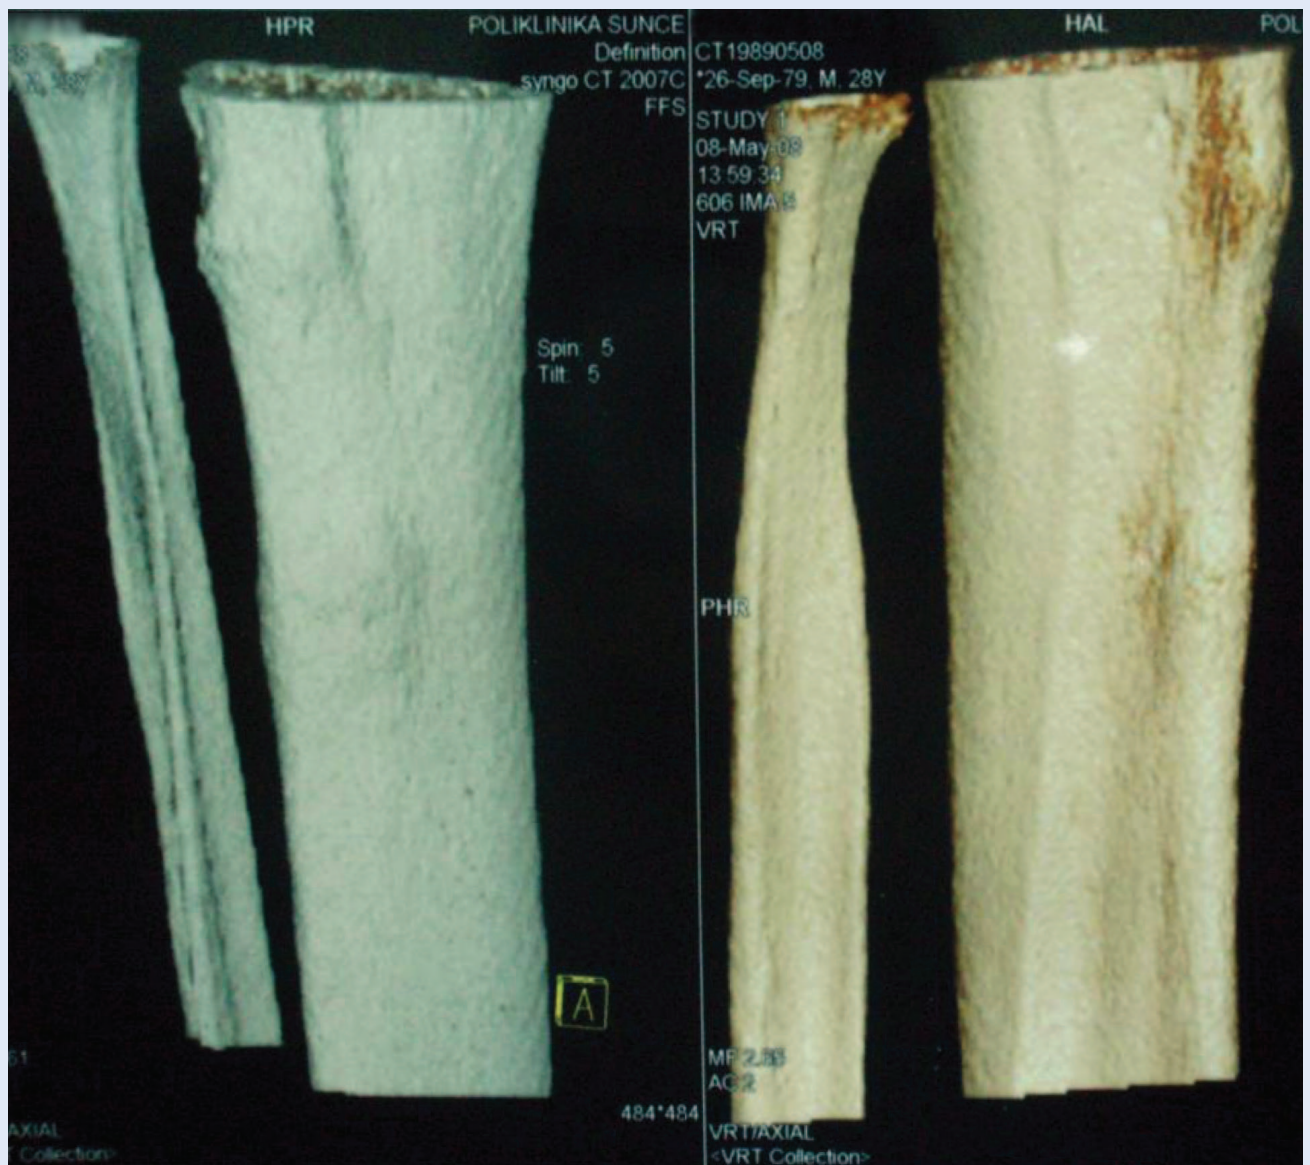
8 May 2008; MSCT axial layers of the right lower leg – 3D and MPR reconstructions, in comparison with a series of earlier scans, oval endostotic change of the ventricular corticalis of the right tibia is barely noticeable. The cross sections show that the earlier formation was much more sclerotic entirely compared to previous CT findings.
